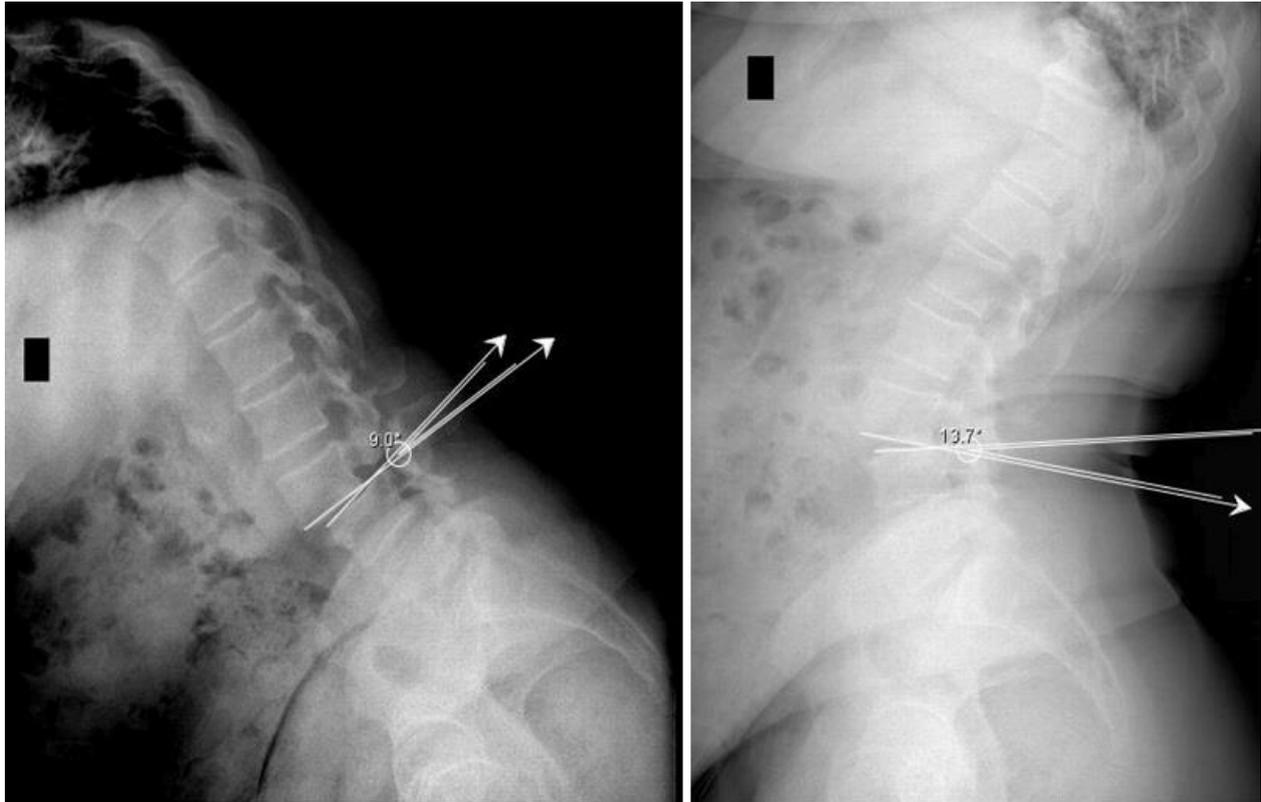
Lumbar dynamic X-ray images which were obtained in the neutral position and in flexion position showing the slippage degrees of patient who was not operated
